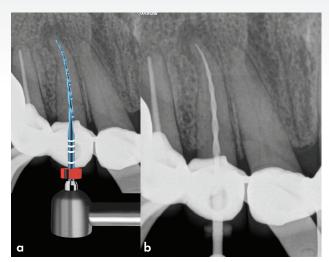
(a) Reciproc Blue R25 was used to full working length, indicated by the file engaging the auto-reverse mode on the X Smart Pro Endodontic motor; (b) Periapical radiograph confirming the progress of the Reciproc Blue R25 instrument to full working length
